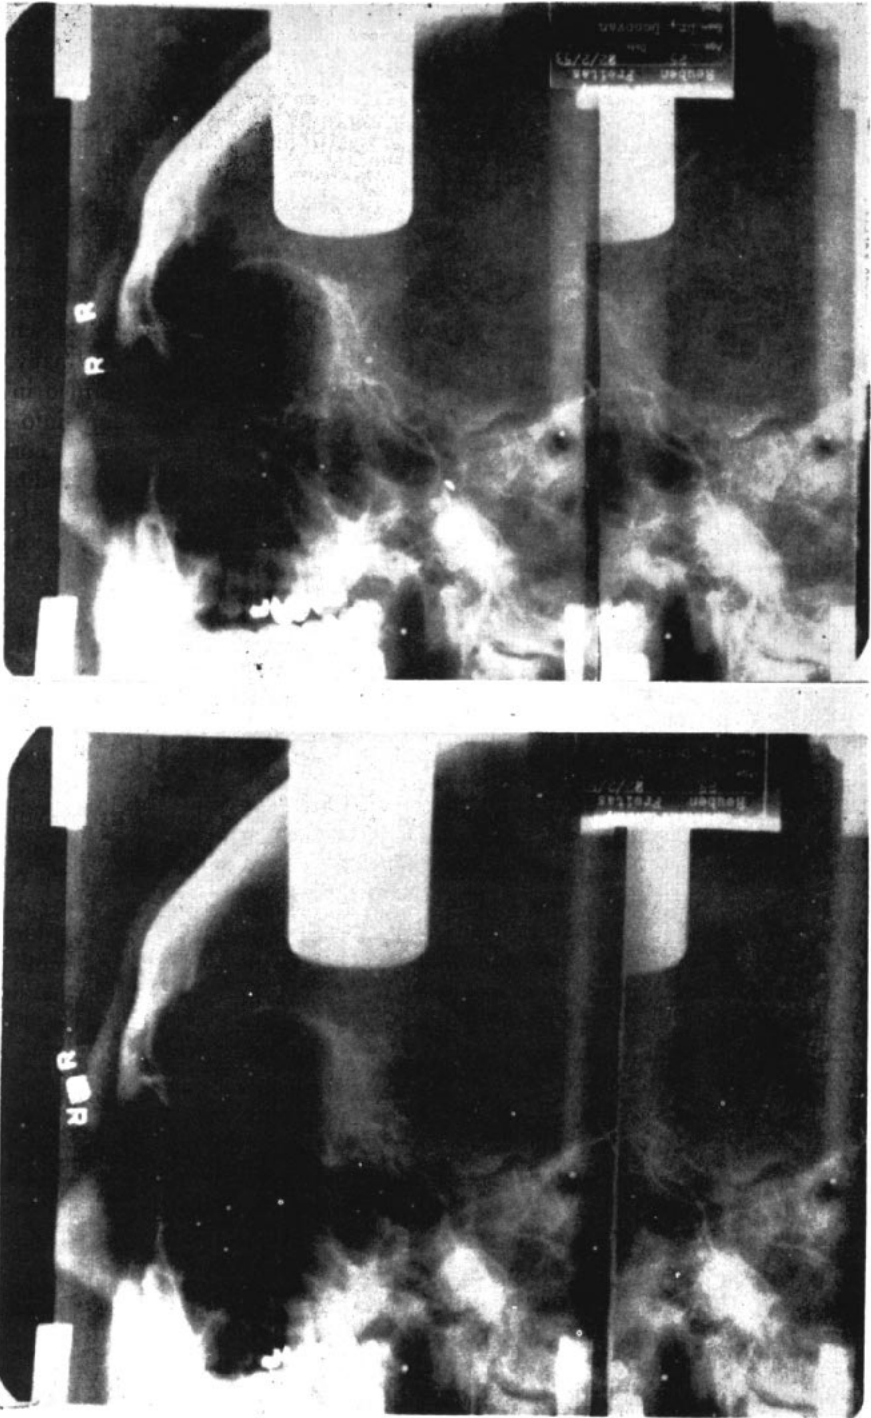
Roentgenographic series of right temporomandibular joint. Above left, rest position. Above right, occlusal position. Below left, retruded position. Below right, incisive position.
